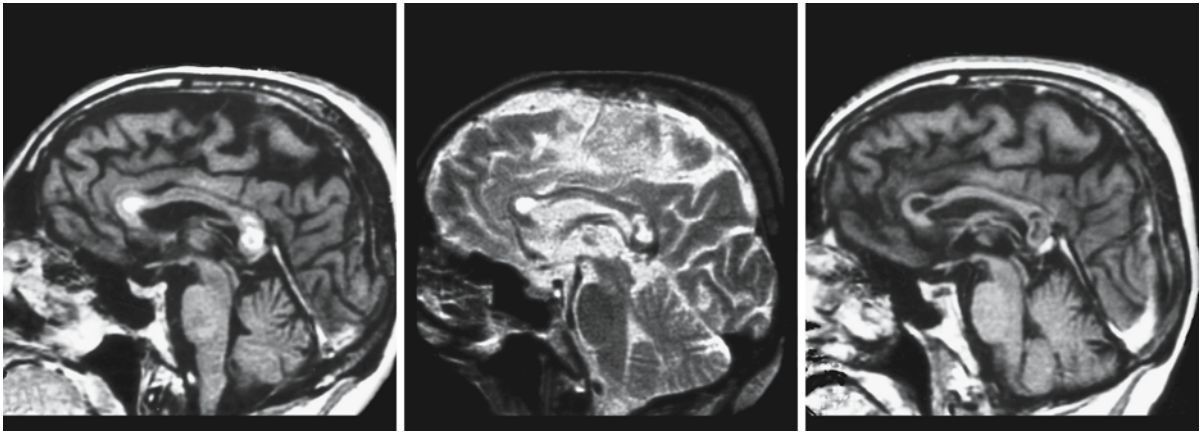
A 53-year-old man with MBS with acute onset. MRI on the ninth day (*left image*) shows contrast-enhancing lesions in the genu and the splenium of the corpus callosum. At 3 weeks the images (*middle and right images*) show involvement
